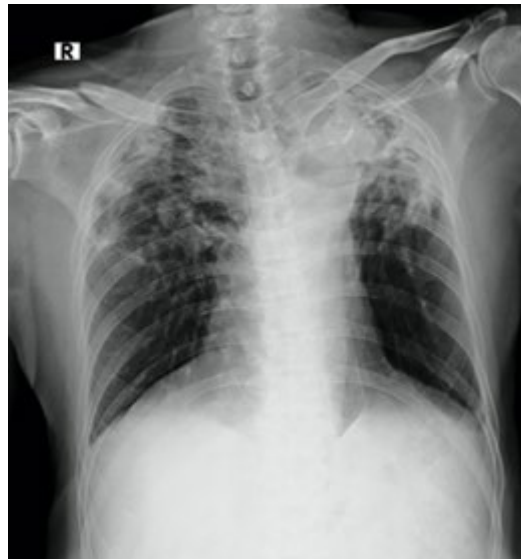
The Result of Chest Anteroposterior X-Ray Imaging Mrs.A
